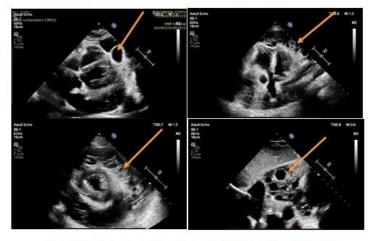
2D echocardiography showing multiple pericardial hydatid cysts
